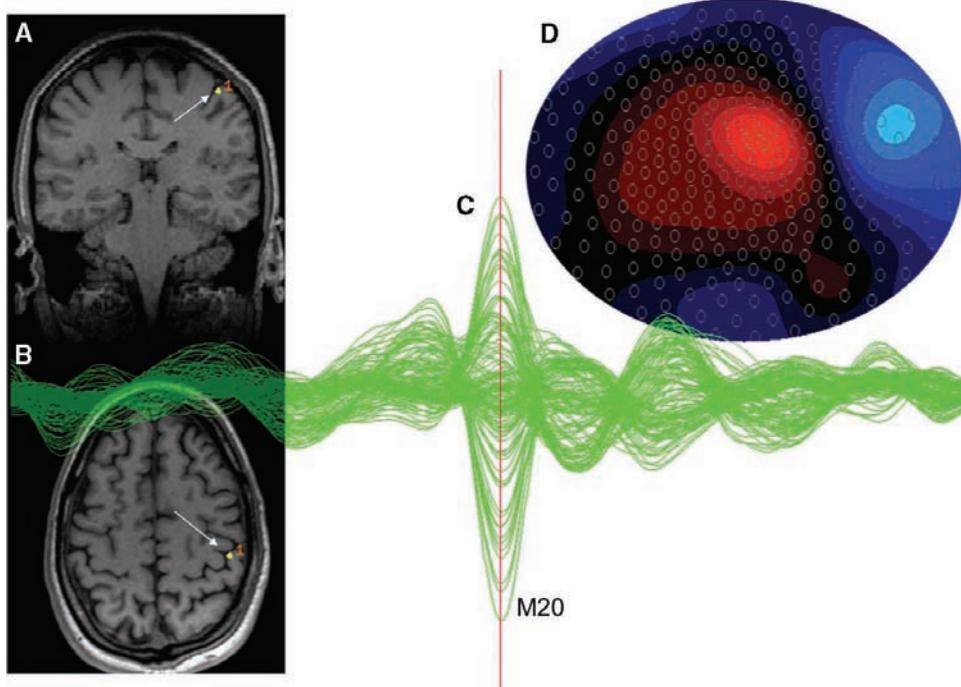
Somatosensory stimulation, evoked responses, and localization. Data from all 275 channels (*overlaid*) show a large response at ~20 ms (M20) to median nerve stimulation (C). The topographic color map (D) shows the magnetic field distribution at the time of the M20 peak. The field pattern is dipolar, with clearly defined regions of emerging (red) and entering (blue) magnetic flux. As shown in the (A) coronal and (B) axial MRI, M20 dipole source localization identified activity in primary somatosensory cortex (postcentral gyrus) (arrow).
